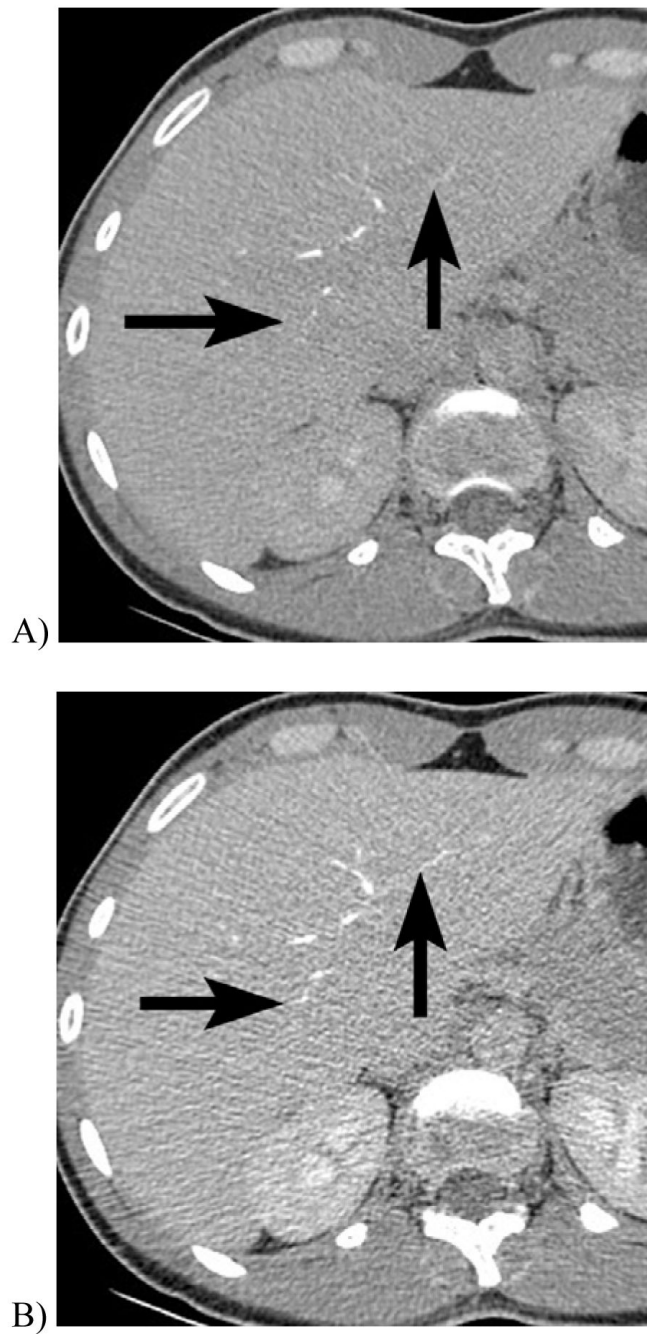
CT cholangiogram of 32 year old woman being evaluated for possible liver donation. Intravenous contrast material that is excreted into the biliary tract in this patient is slightly less conspicuous when the scan is obtained at 140 kVp/200 mA (A) than at 100 kVp/400 mA (B), but the image noise is lower with the high kVp setting. In this case, the iodinated contrast in the renal medulla is more conspicuous at the lower kVp setting, despite the higher image noise. In larger patients, image noise at low kVp settings may obscure fine detail.
